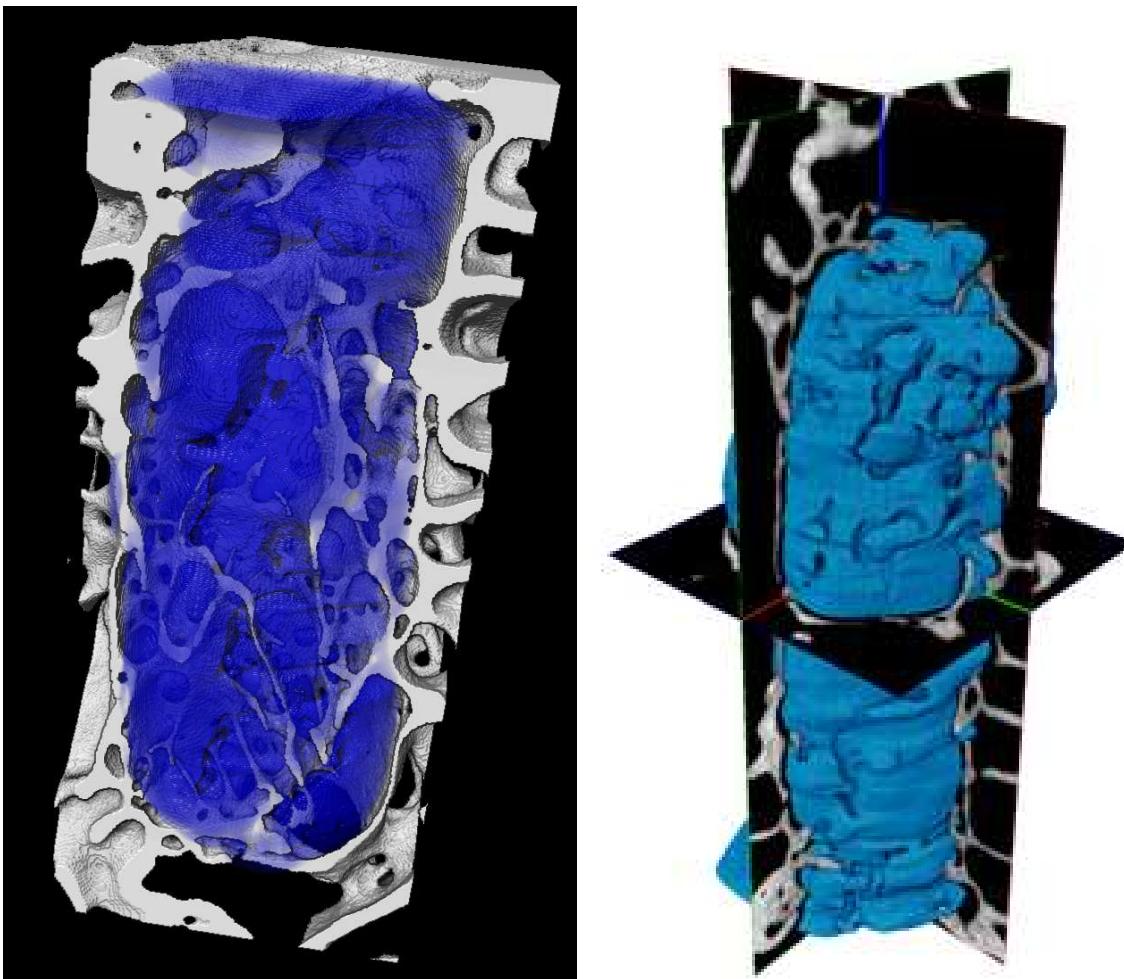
Two 3D reconstructions of the μ CT images at 104 week time point. Blue color represents the sample material and white color represents bone tissue. Images provided by Tampere University.
